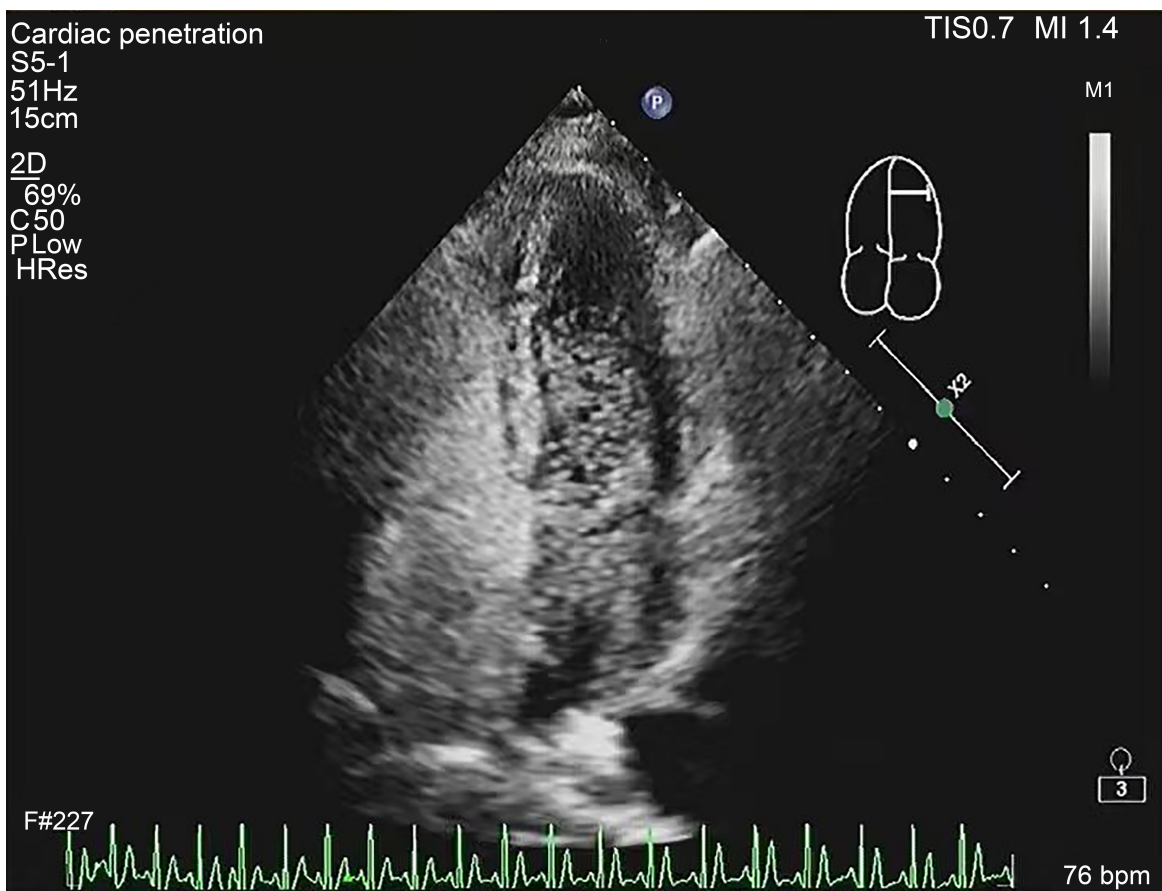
Right heart contrast echocardiography in Valsalva state.
